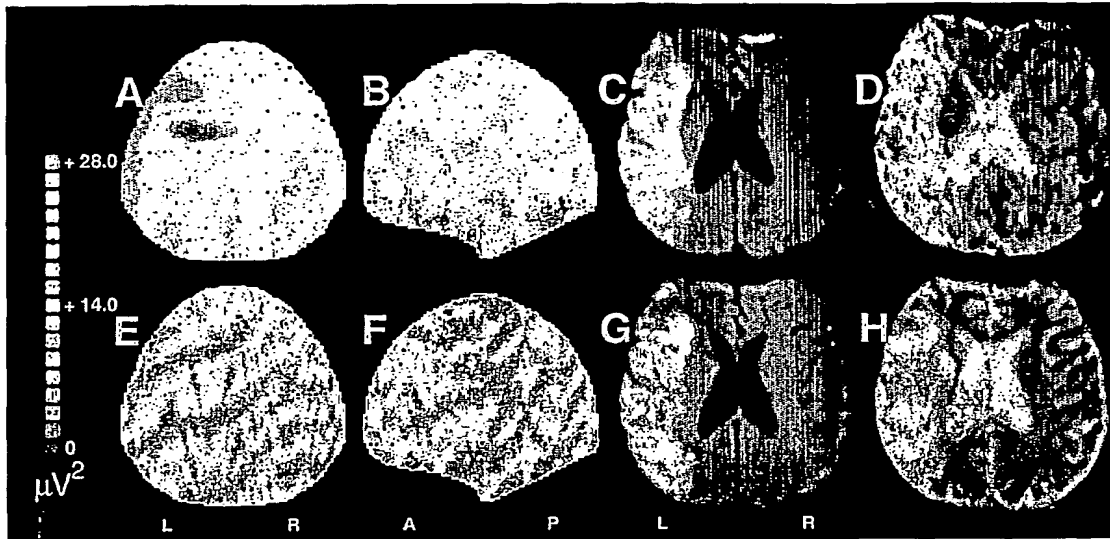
EEG and MRI data from a patient who received recombinant tissue Plasminogen Activator. A and B: Axial and left lateral DPM acquired 6 hours after onset of symptoms; C: initial DWI (4.5 hours); D: initial MTT map; E and F Axial and lateral DPM at 12 hours; G: 13 hour DWI scan and H: 30 day T2 MRI.
